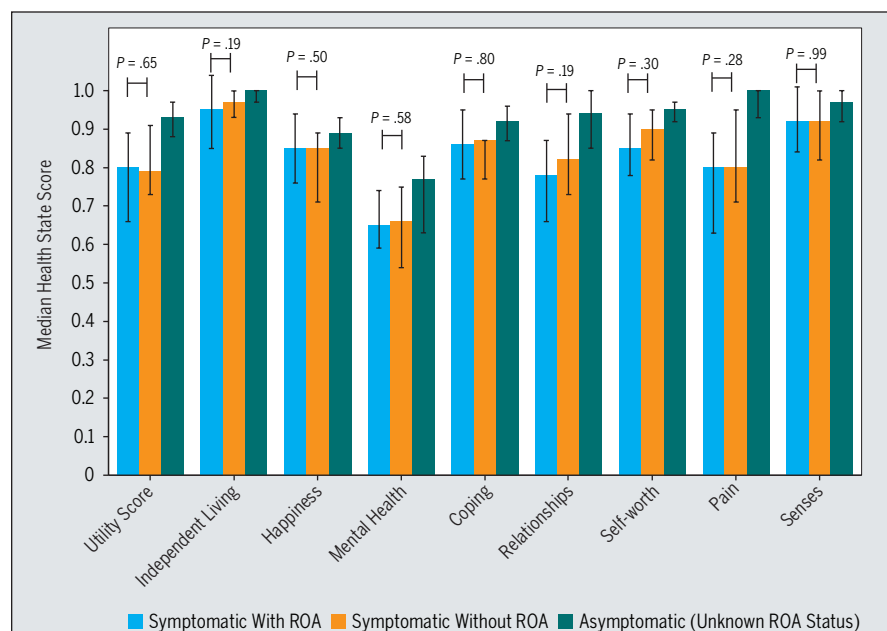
Comparison of Assessment of Quality of Life-8 Dimensions utility scores in symptomatic people after ACL reconstruction (with and without ROA) and asymptomatic participants. All outcomes were reported as medians, and error bars represent interquartile ranges. A score of 1.0 represents the best possible score. P values were obtained using Mann-Whitney U tests and are reported for symptomatic with ROA (blue) versus symptomatic without ROA (orange). Abbreviations: ACL, anterior cruciate ligament; ROA, radiographic osteoarthritis.
